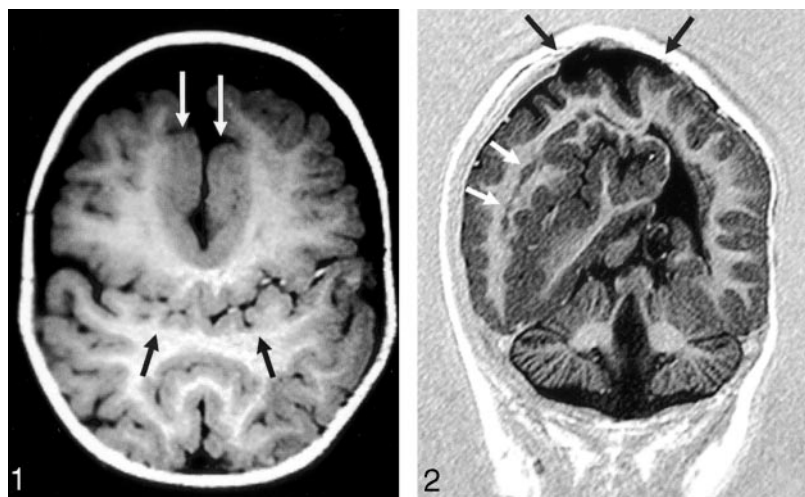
Axial T1-weighted image (550/14/2 [TR/TE/excitations]) in the posterior frontal and parietal regions shows the abnormal sylvian fissures communicating across the midline over the vertex (black arrows). Flow-related enhancement is seen within branches of the middle cerebral arteries, confirming that this represents the sylvian fissure. Thickened dysplastic cortex is present along the anterior IHF (white arrows).
